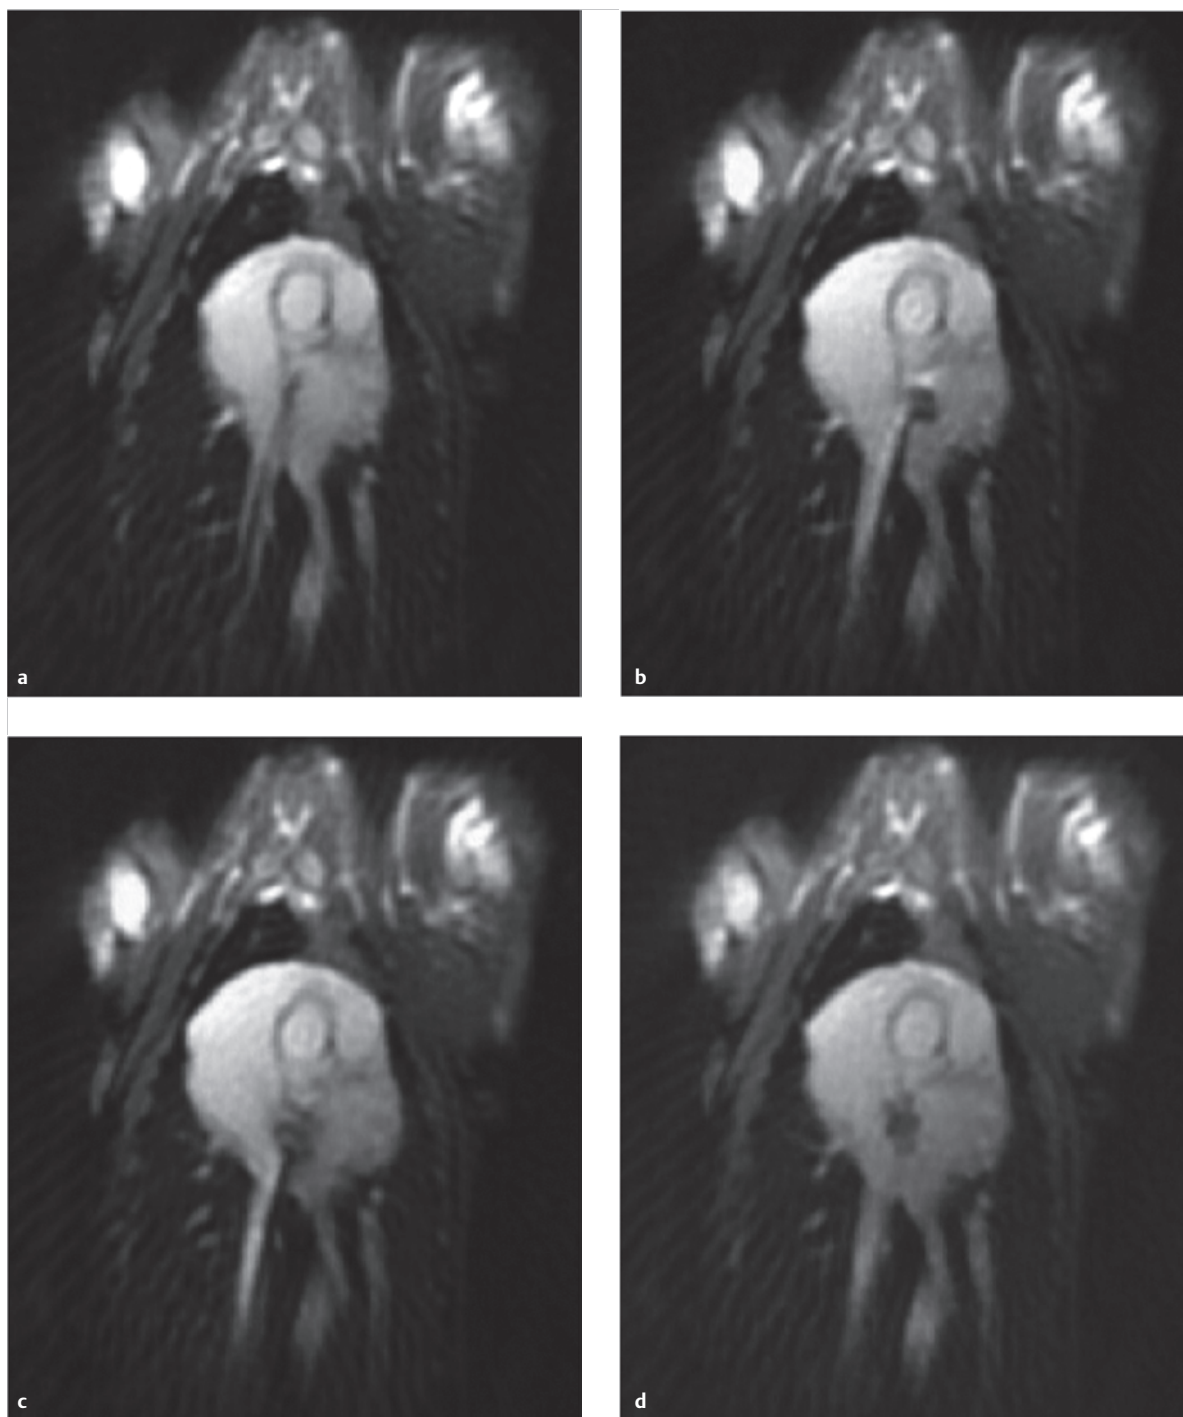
Placement of atrial septal occlusion devices under real-time MRI guidance.
